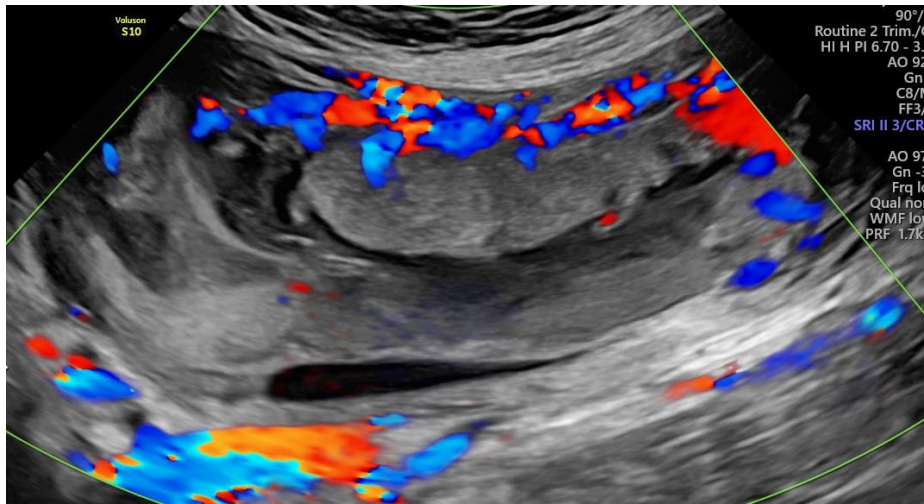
Placental Hematoma. Color Doppler Ultrasound (Longitudinal plane).
